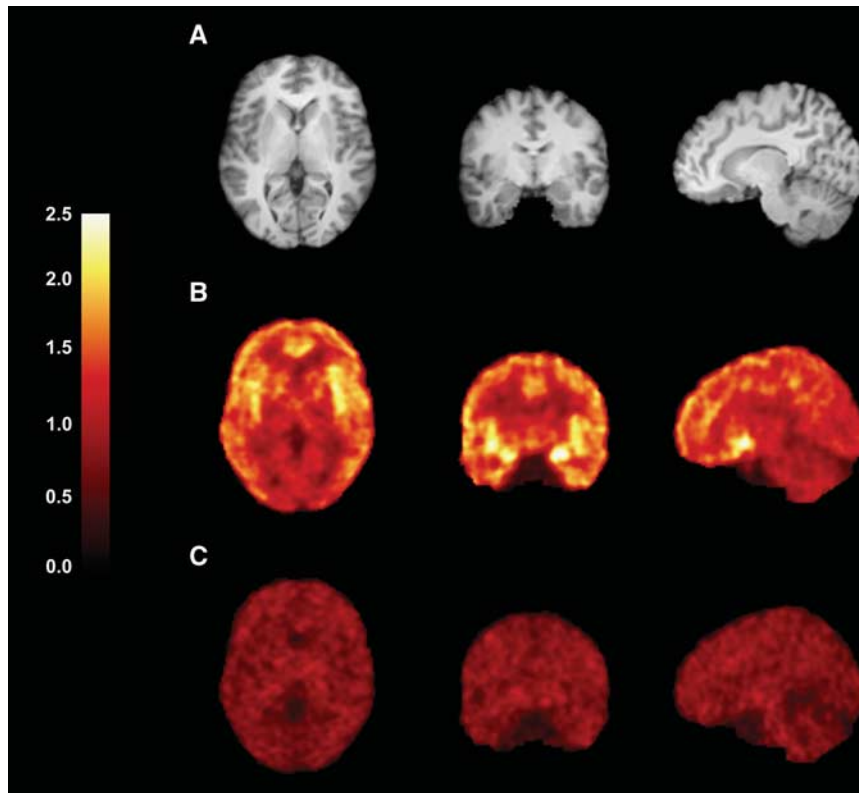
Images from a typical subject (female, 32 years old, 77 kg body weight). (A) Magnetic resonance (MR) images. (B and C) Coregistered positron emission tomography (PET) images summed from 30 to 90 minutes after injection of ^{11}C -LY2795050. (B) Baseline scan and (C) postnaltraxone scan. Activity is expressed as SUV (concentration/injected dose/body weight). PET images were spatially smoothed by three-dimensional Gaussian filter with full width at half maximum (FWHM) (3.6 mm). SUV, standard uptake value.
